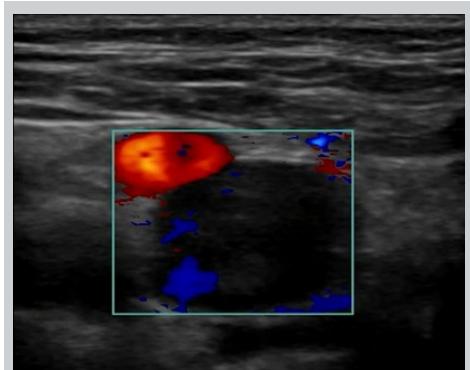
Right femoral vein incompressible, with absent Doppler flow in femoral vein confirmed DVT.
